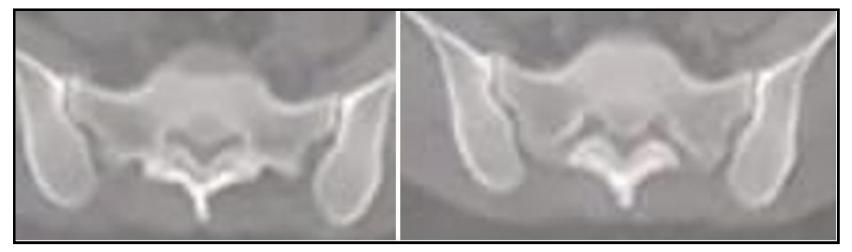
CT scan of L5-S1 level showing marked hypertrophy of ligamentum flavum with narrowing of spinal canal (Red arrow).
